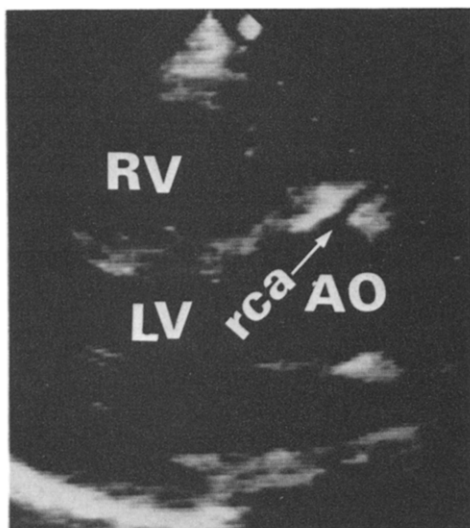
Parasternal long-axis view showing the origin of a large right coronary artery (rca) from the anterior aspect of the aorta (AO). This view was obtained from a patient with origin of the anterior descending artery from the right coronary artery. The right coronary artery (rca) is visible in this view because of clockwise rotation of the aortic cusps (viewed from below; see text). LV = left ventricle; RV = right ventricle.
